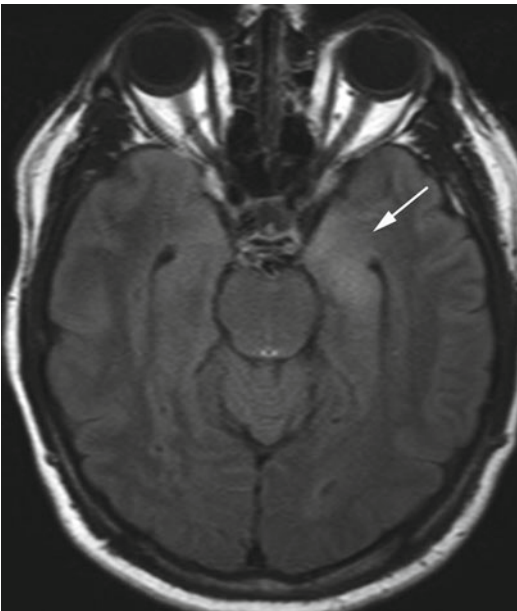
Paraneoplastic limbic encephalitis. Axial FLAIR image reveals faintly increased signal in the left temporal lobe (*arrow*)
